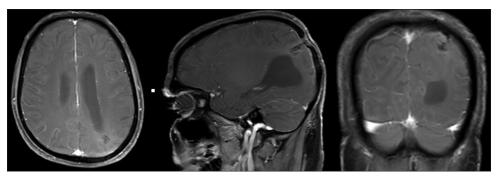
Follow-up contract-enhanced magnetic resonance imaging at 12 months showing complete radiological resolution of the lesion and the surrounding edema
